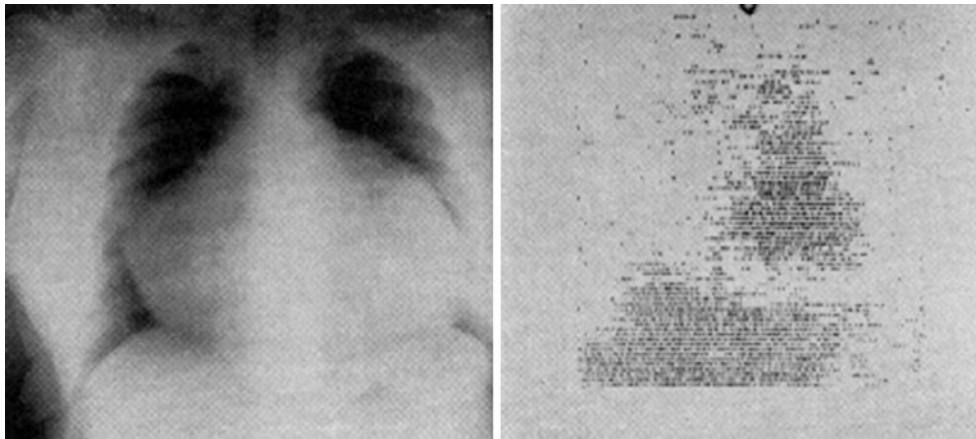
Scan demonstrating marked discrepancy in transverse diameters between the cardiac blood pool and cardiac silhouette seen on the roentgenogram [9]
